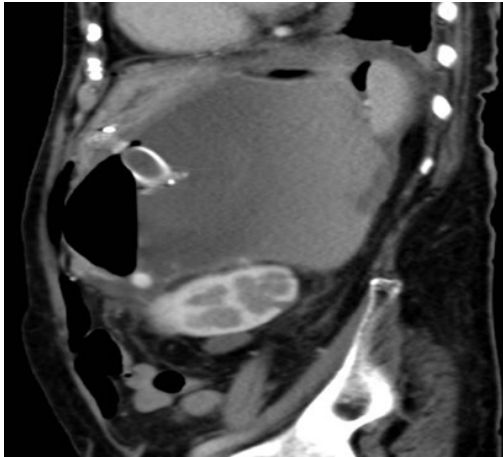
CT abdomen showing stent in situ and resolving pneumoperitoneum.
